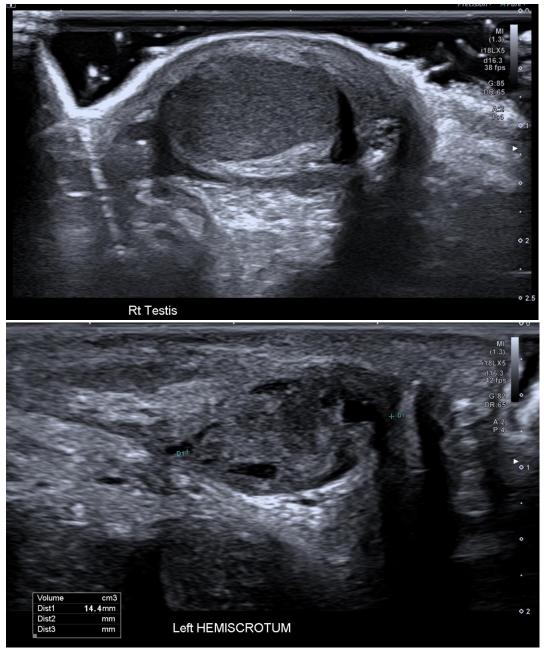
ultrasound scrotum demonstrating right testis with normal echo pattern and 14 mm heterogeneous focus in the left hemiscrotum with internal vascularity.
